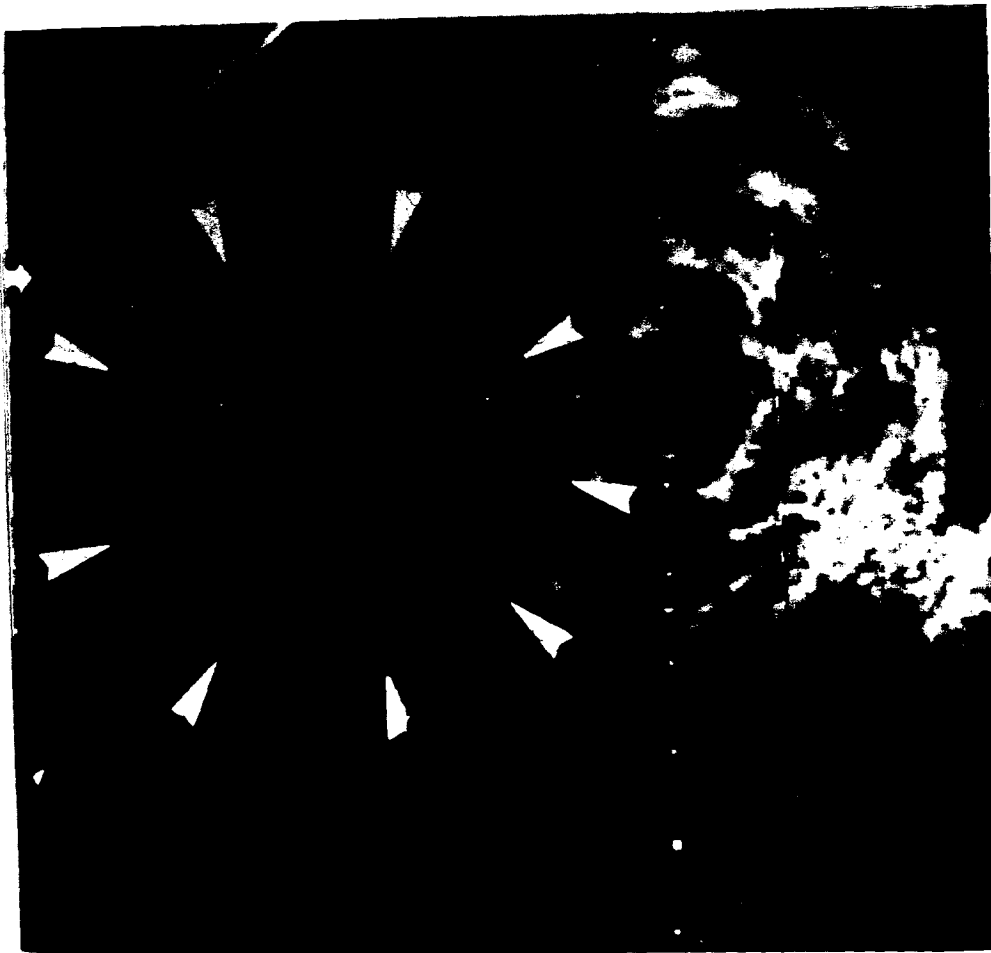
Short-axis view of the left ventricle at midpapillary muscle level with a 10-Fr, 10-MHz intracardiac ultrasound catheter.
